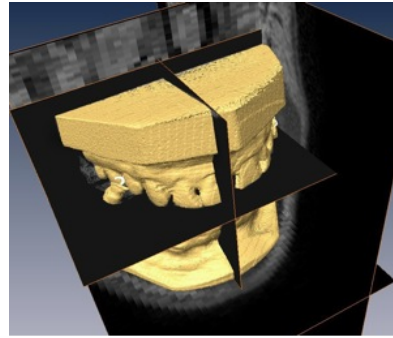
Registration of MRI scan to cone CT scan of dental cast.
